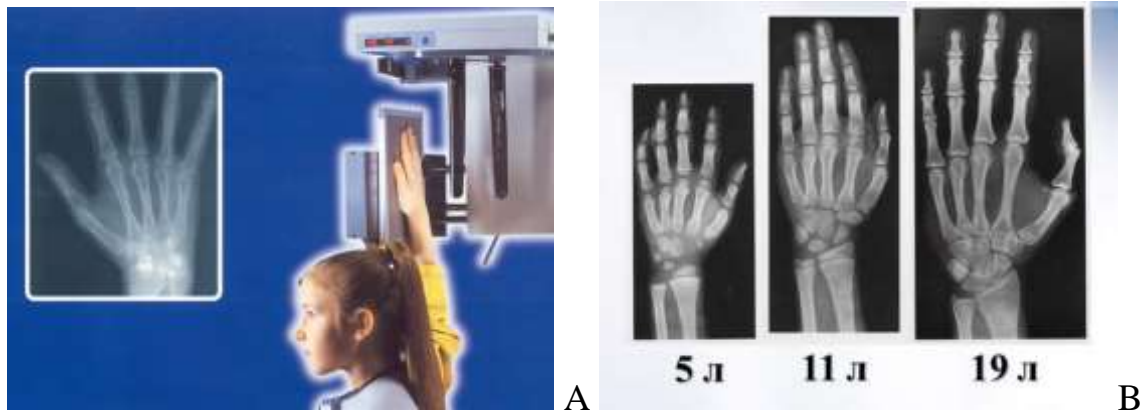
Hand-wrist radiography.
